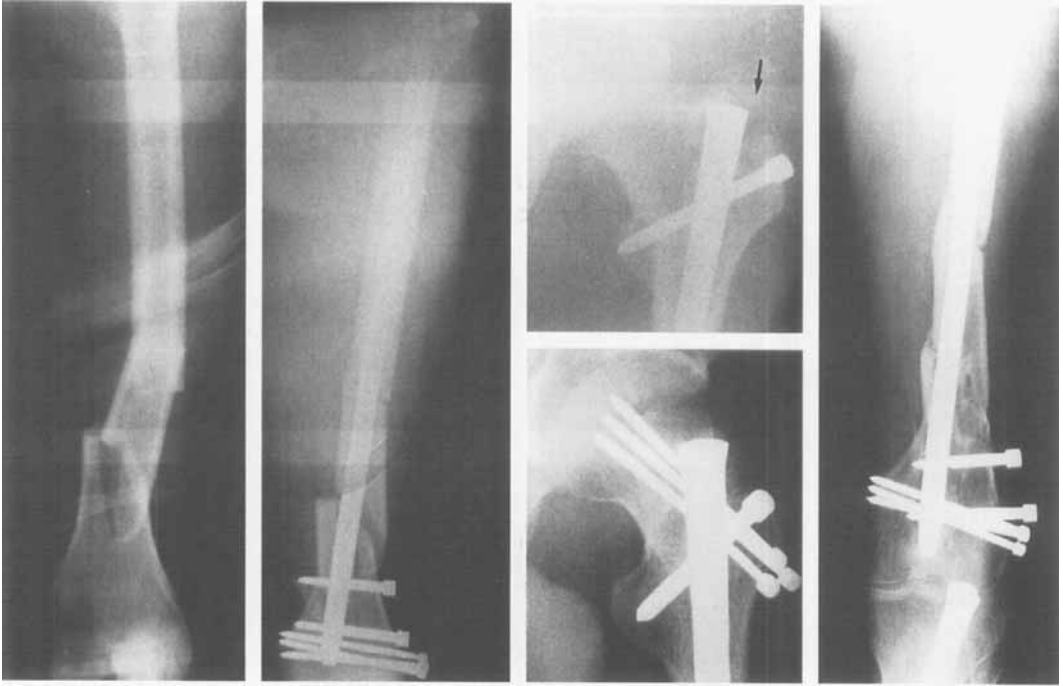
Case 8. A 50-year-old man sustained left segmental femoral shaft and intercondylar fractures. Closed multiple Knowles' pinning was done first for the intercondylar fracture and closed static locked nailing followed for the segmental shaft fracture. An iatrogenic femoral neck fracture was noted immediately postoperatively and closed multiple Knowles' pins were inserted. All fractures healed at 5 months. The femoral head was radiographically normal at 3-year follow-up.
